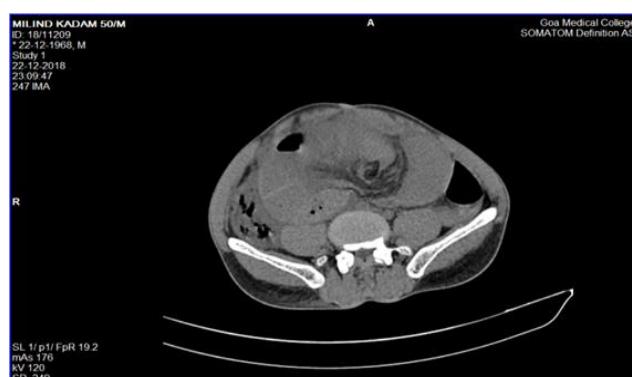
CT scan depicting dilated small bowel loops within the hernial sac with twisting of mesentery.
